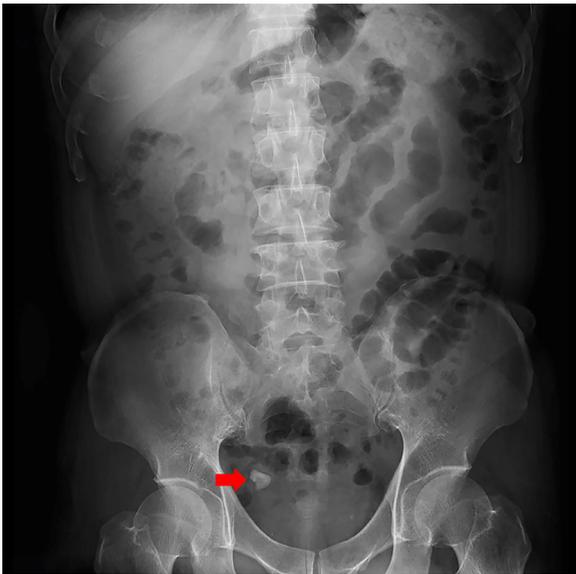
A plain abdominal radiography taken on day 2 revealed that the gallstone had moved to the sigmoid colon.
